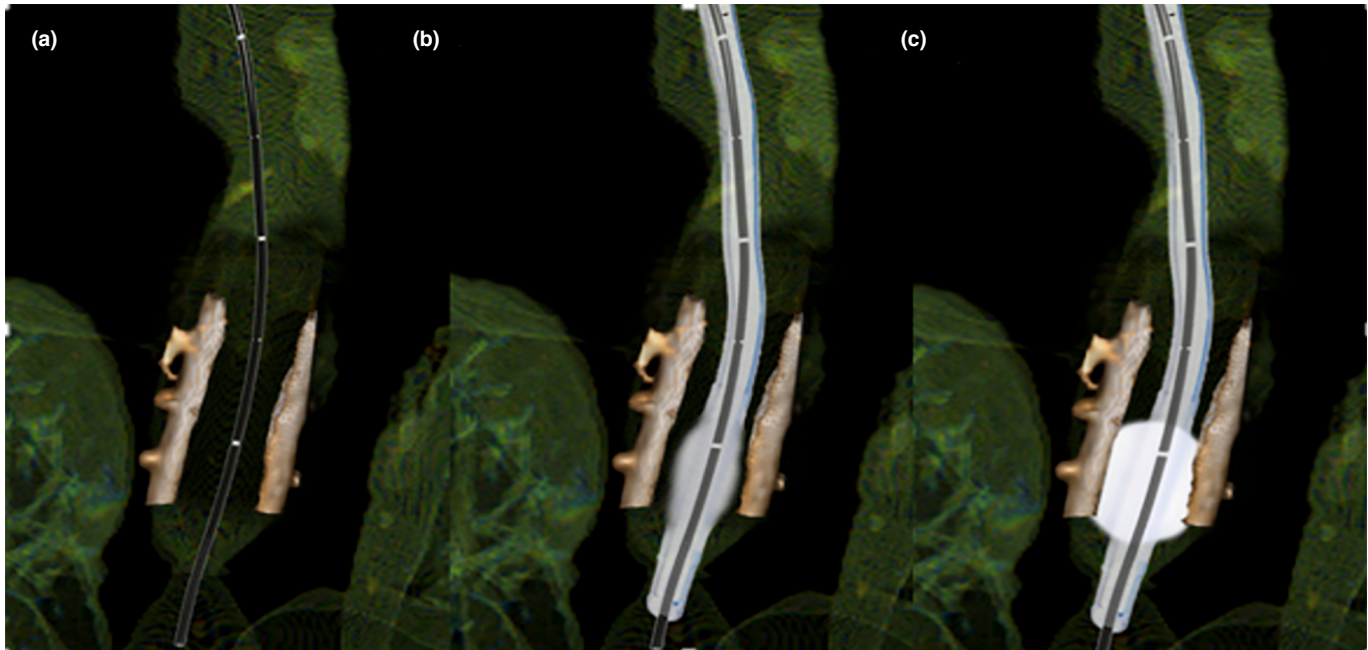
Demonstration of the procedure using the patient's computed tomography images. (a) Evaluation of the airway and the stent using a flexible bronchoscope. (b) Placement of a 6-mm-diameter endotracheal tube into the stent under guidance of a thin bronchoscope. (c) En bloc removal of the stent together with the endotracheal tube after cuff inflation under thin bronchoscope guidance
